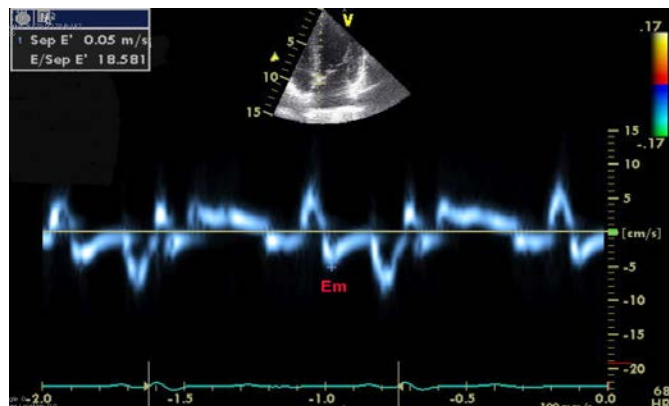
Example of a pulsed-wave tissue Doppler velocity trace of the mitral annulus. The peak mitral annular early diastolic relaxation velocity (E_m) was recorded as shown. In this example taken from the septal mitral annulus of a patient with dilated cardiomyopathy, $E_m = 5\text{cm/s}$ which is significantly reduced.
